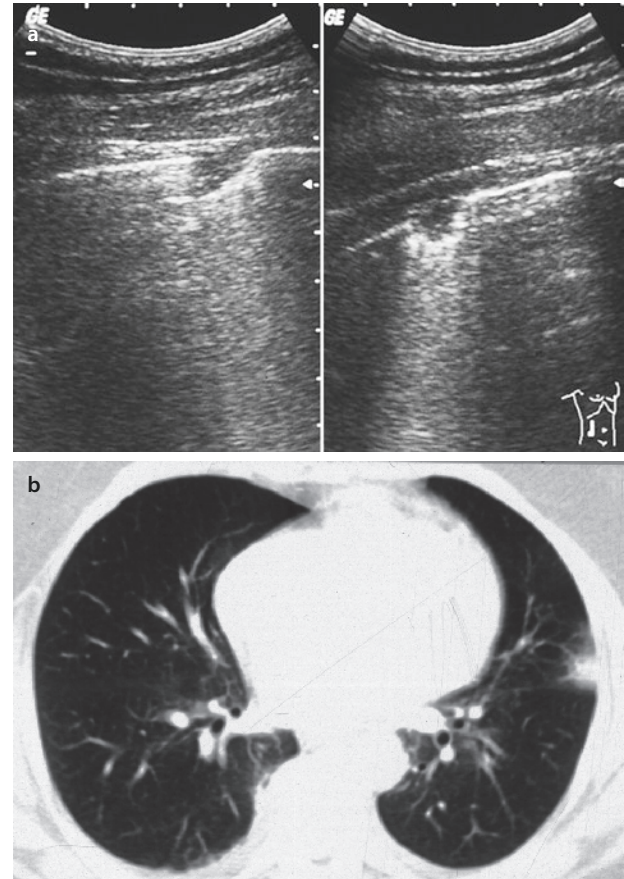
A 25-year-old woman with sudden dyspnea and mild respiratory chest pain. a Sonography revealed two small pulmonary infarctions. b On spiral computed tomography the central pulmonary embolism was confirmed and only one lesion was seen in the periphery
